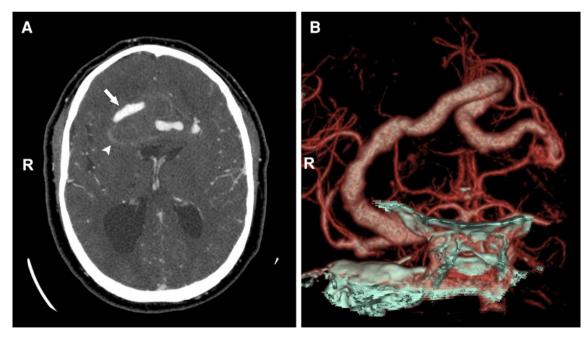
a Axial contrast-enhanced CT brain scan showing a large 5 cm diameter oval mass with a calcified and ring-enhancing margin (*arrowhead*). The lumen of the aneurysm (*arrow*) is surrounded by
